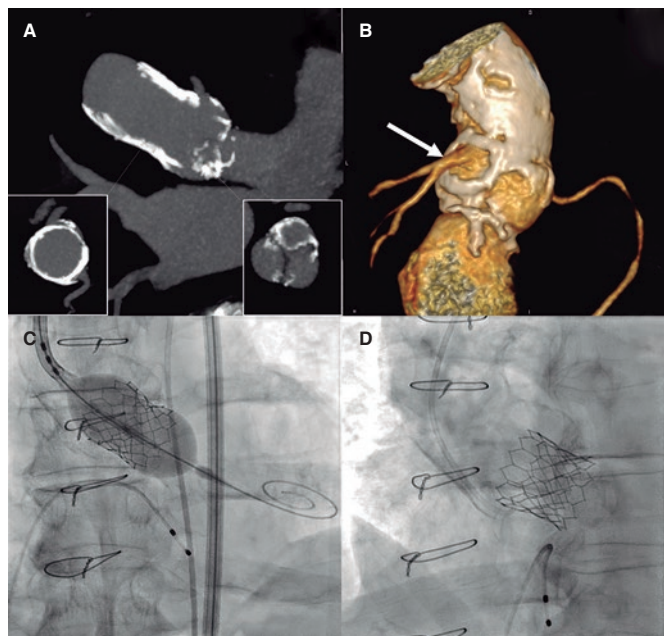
A: multiplanar reconstructed computed tomography images showing the calcified homograft (cross-sectional view in the left lower quadrant) with less calcification in the aortic valve (cross-sectional view in the right lower quadrant). B: 3D reconstruction of the aortic root through computed tomography scan with posterior view showing severe calcification of the homograft that preserves the left main coronary artery neo-ostium (arrow). C: implantation of a SAPIEN 3 Ultra 26 mm aortic valve (Edwards Lifesciences, United States) with incomplete expansion that is completed in a second inflation. D: final angiographic image showing severe calcification of the homograft with a properly expanded valve.
